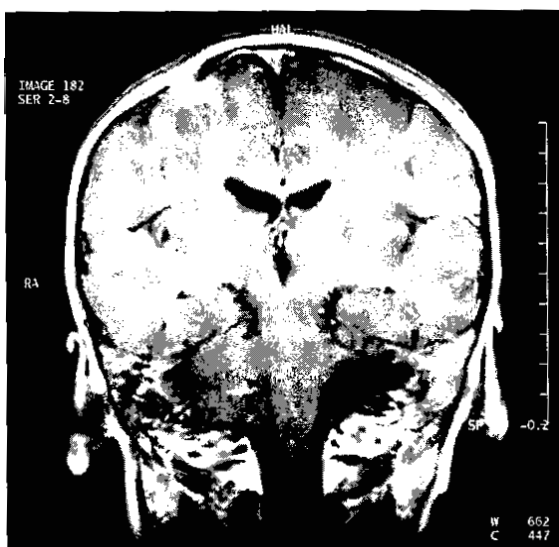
Case 3 at language testing (2 years 4 months post treatment): Coronal and axial MRI scans indicating residual tumour in brainstem and cerebellum post surgery and chemotherapy treatment.
